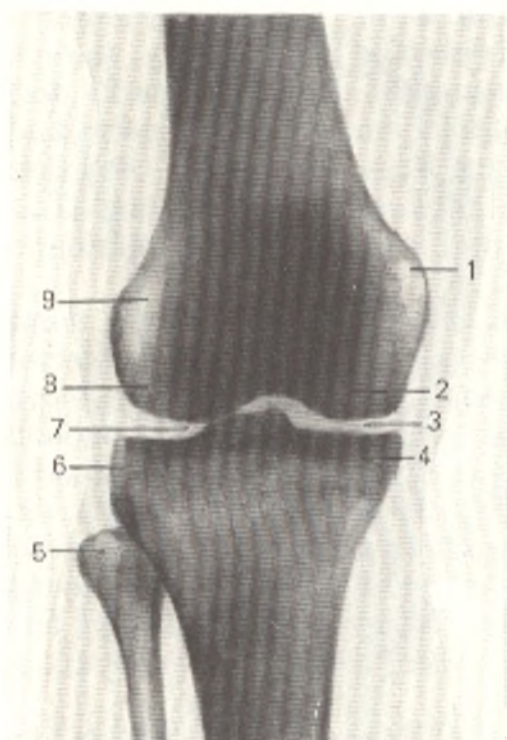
Radiograph of knee joint.
